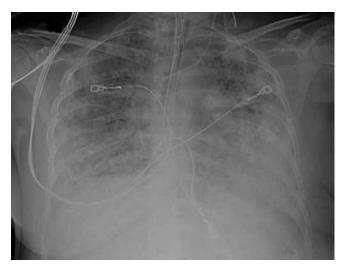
Anteroposterior chest radiograph of a secondtrimester pregnant woman with marked bilateral parenchymal and pleural opacification secondary to acute respiratory distress syndrome (ARDS).
